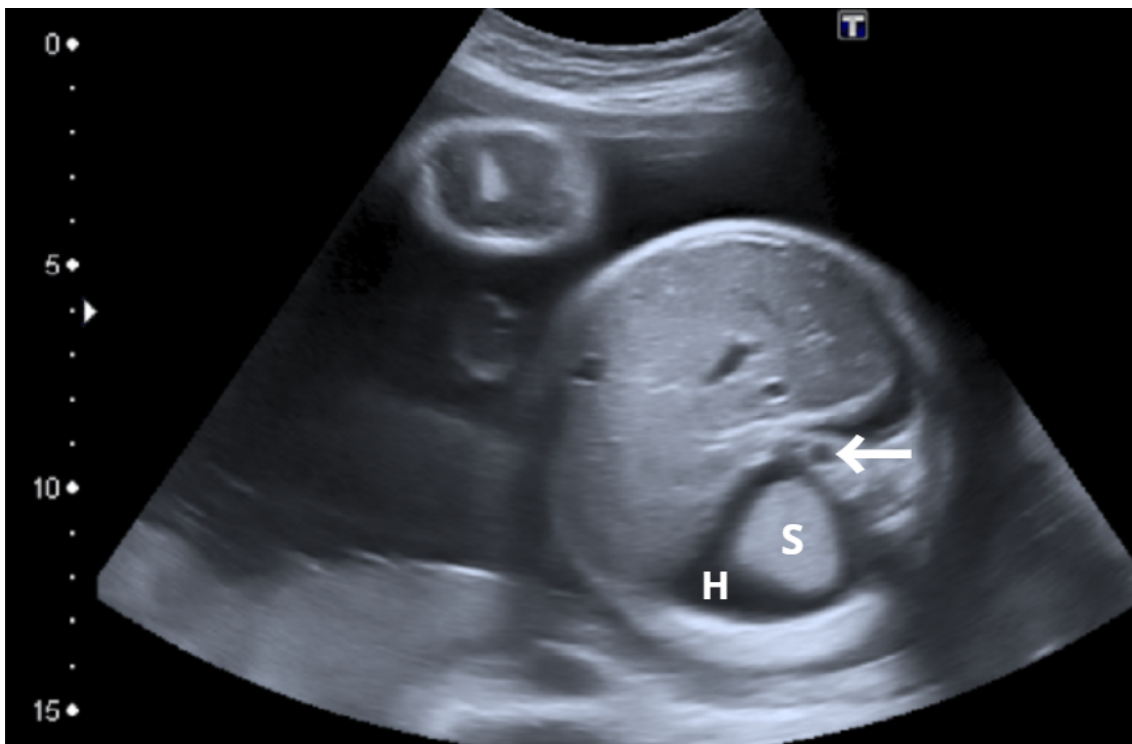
A fetal ultrasound, week 31+6. Abnormal derivative in the thoracic cavity (S) and hydrothorax (H), the white arrow pointing to the aorta.
